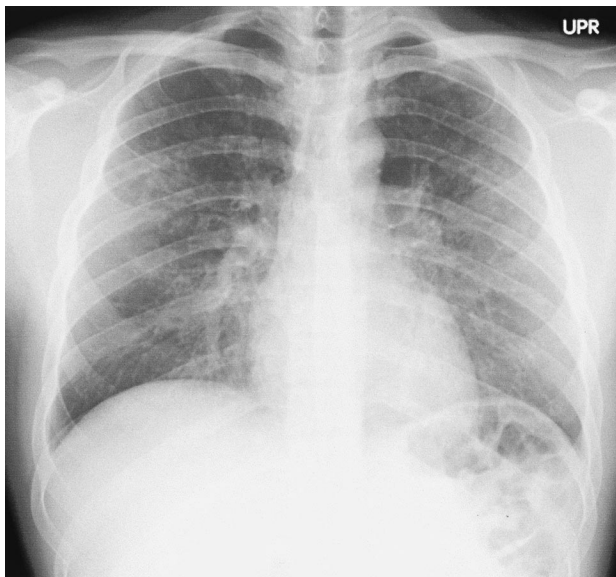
Chest radiograph obtained 36 hours after chlorine inhalation shows diffuse nodular opacities in both lungs.
